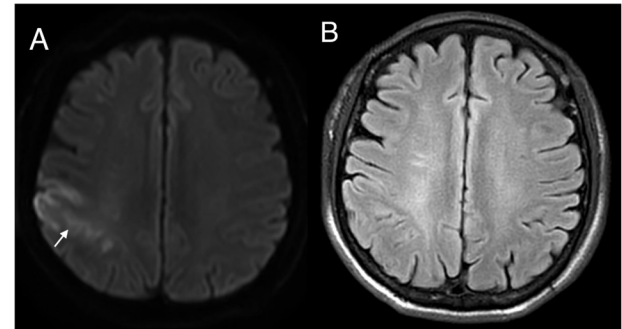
A – Axial DWI image (b=1000) showing right sided pre- and post-central gyrus acute infarct (white arrow). B – Axial FLAIR image at the same region shows no signal abnormality (FLAIR-negative).
